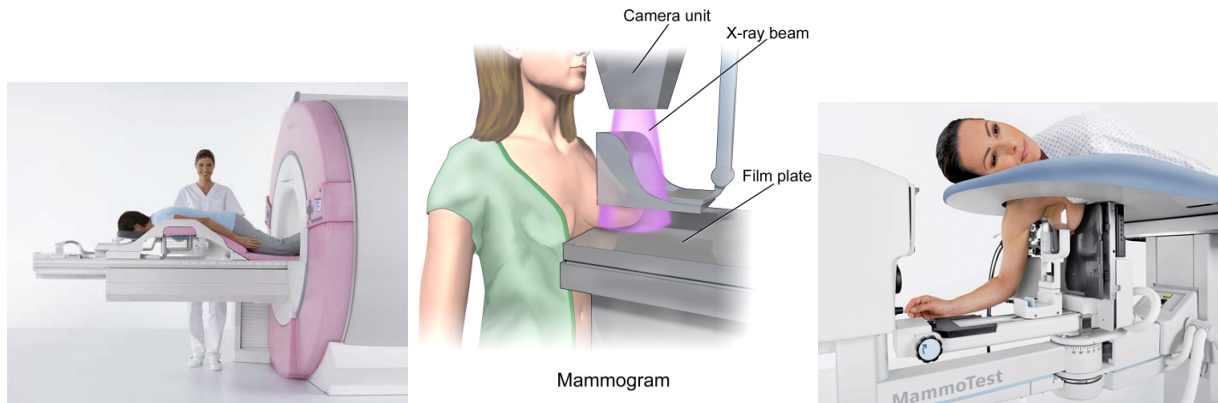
Imaging situation of each modality: MR image in a prone position (left) (118), X-ray mammography in an upright standing position (middle) (37), and spot mammogram in a prone position (right) (83).
